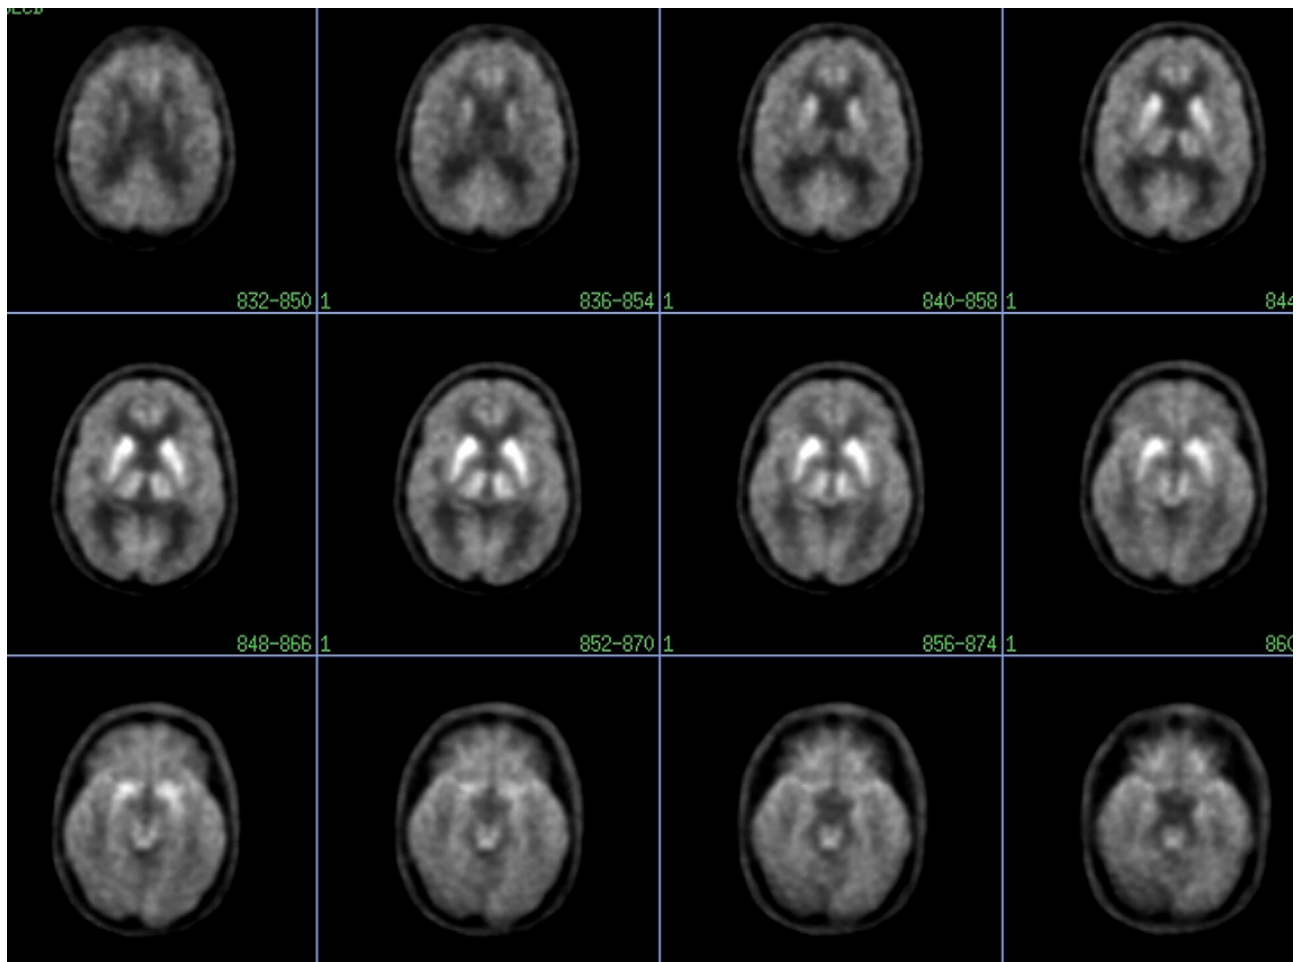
FDG-PET scan of a patient with major depression showing global cortical decrease in metabolism relative to the subcortical structures.
